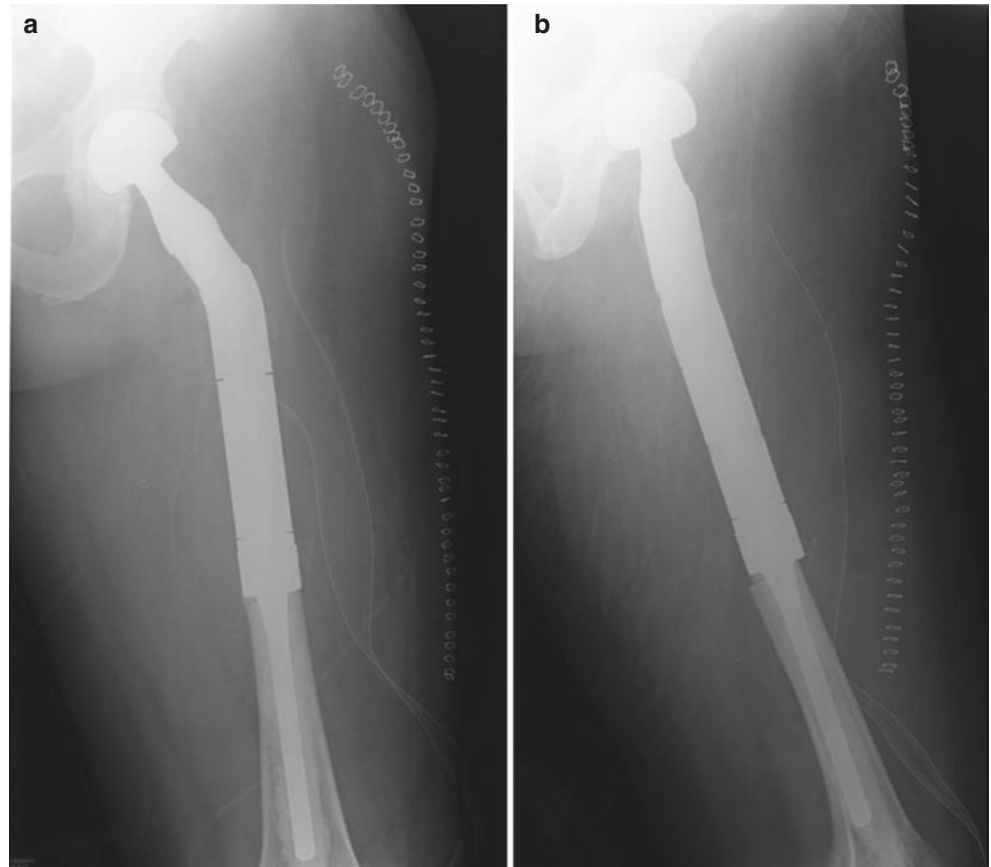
12-year postoperative radiographs reveal intact prosthesis without aseptic loosening or hip joint instability in anteroposterior view (a and b) and lateral view (c)
